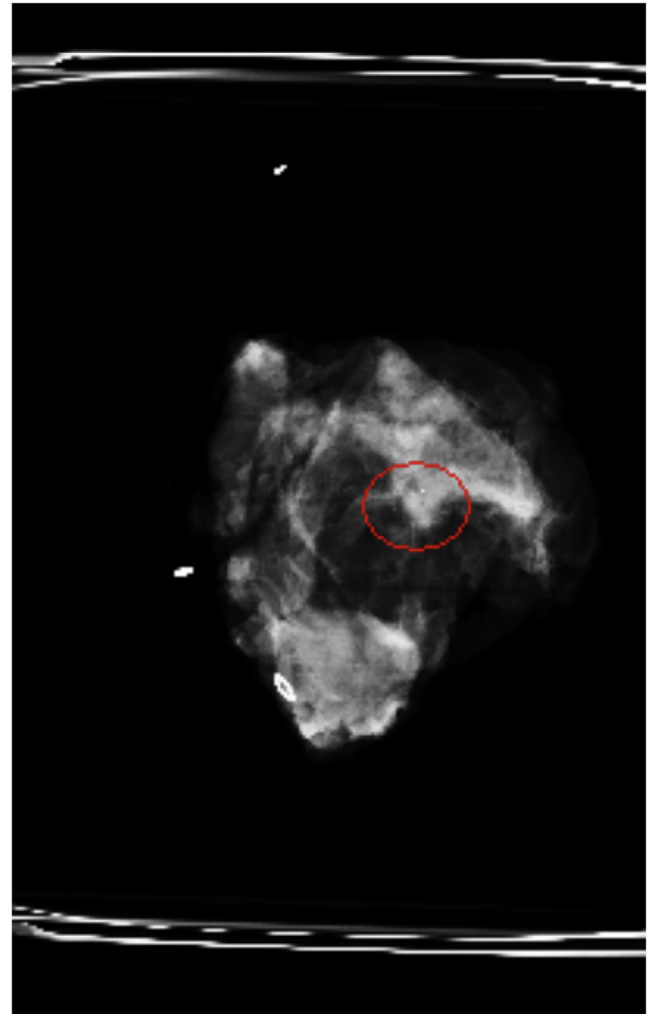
Radiographic examination showing the radicality of the middle-outer lumpectomy.
